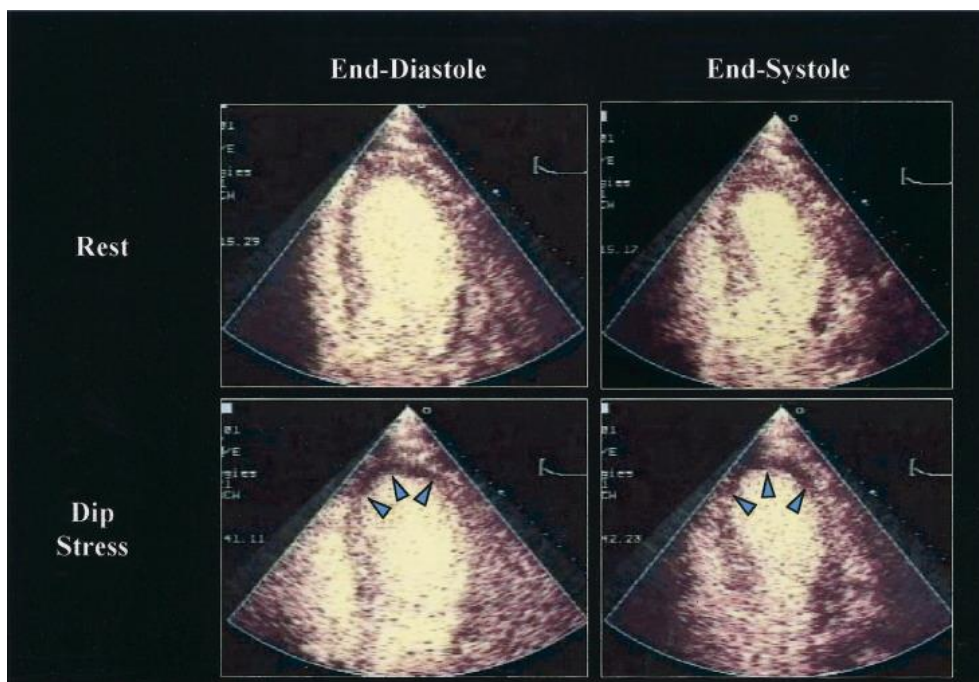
Pictures of a patient's heart taken during a dipyridamole (Dip) stress contrast echocardiogram reveal significant stenosis of the left anterior descending coronary artery ⁽²³⁾.
